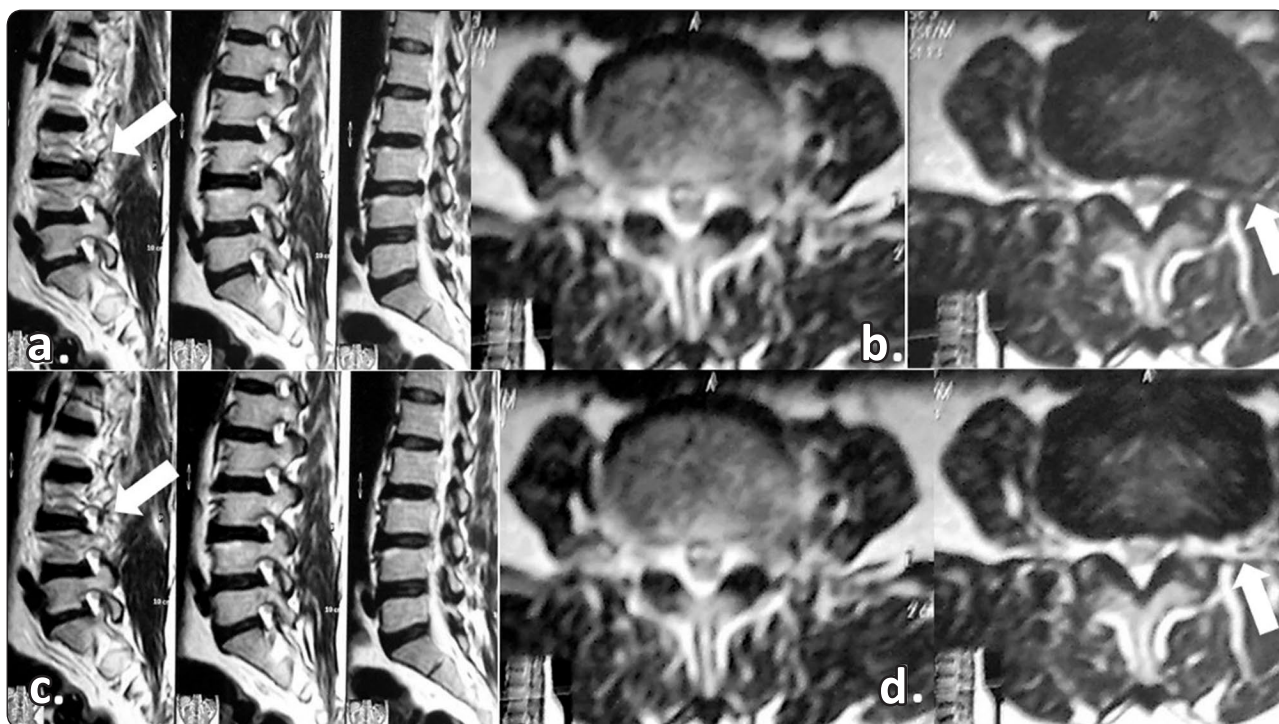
A 55-year-old female patient presented with left-side L3-4 far lateral lumbar disc herniation. (a,b): Preoperative MRI. The white arrows indicate the extraforaminal disc. (c,d): One-year follow-up MRI. The extraforaminal disc was completely removed.
